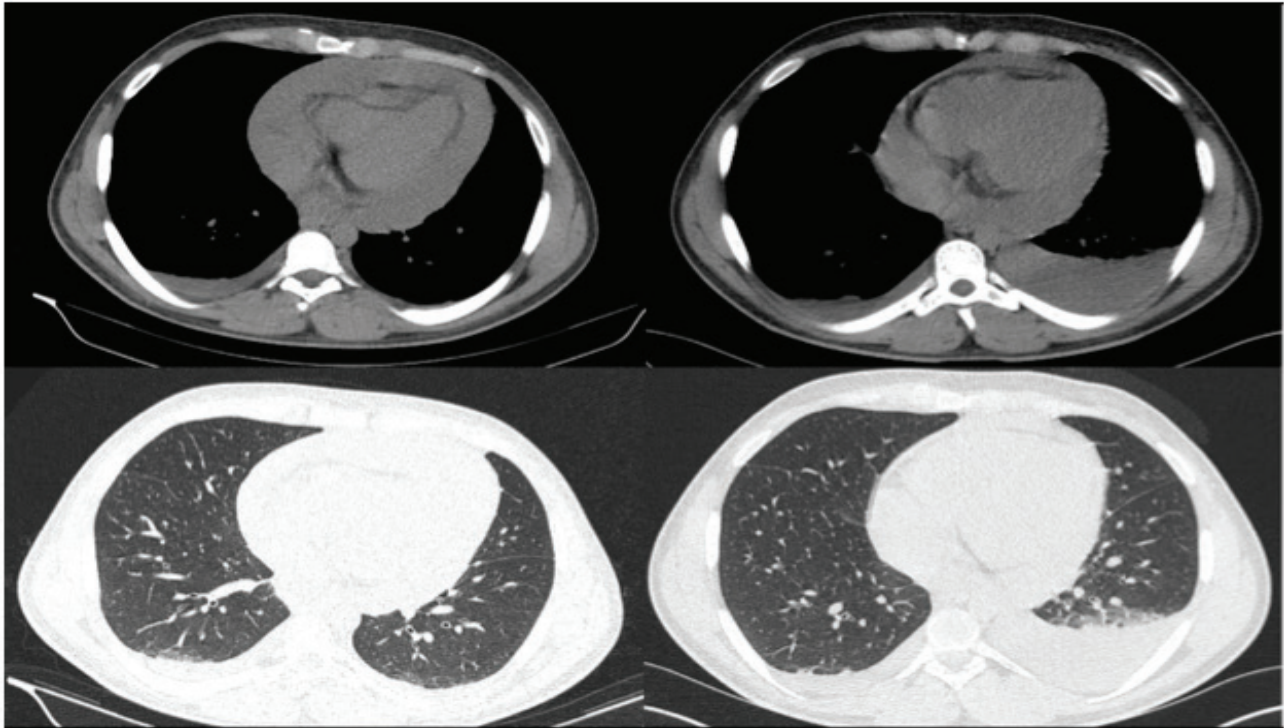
Left side CT images were taken before PC; in right side images after PC representing increase of left pleural effusion
